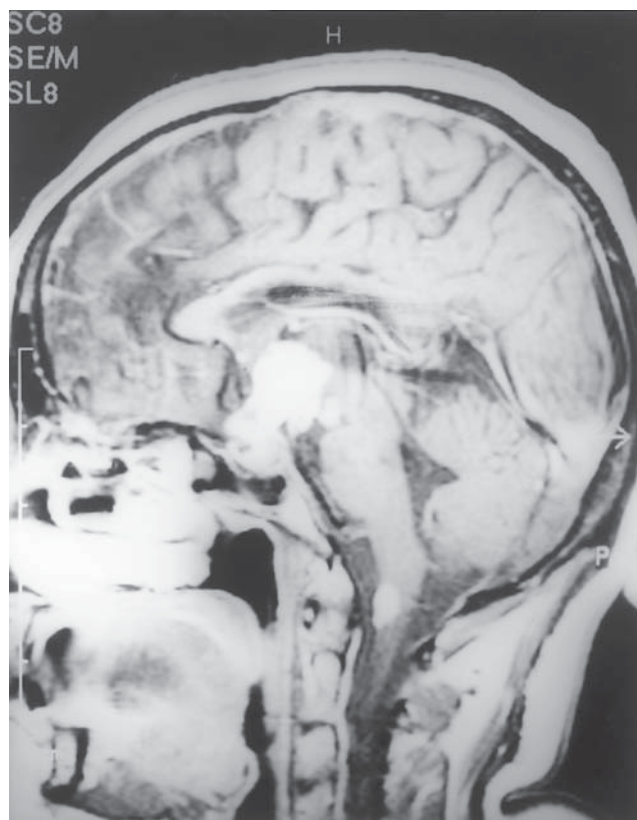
Magnetic resonance imaging (sagittal section) showing a hypothalamic mass with intracranial and spinal deposits. The hypothalamic mass is seen to extend toward, but not involve, the pituitary gland.
